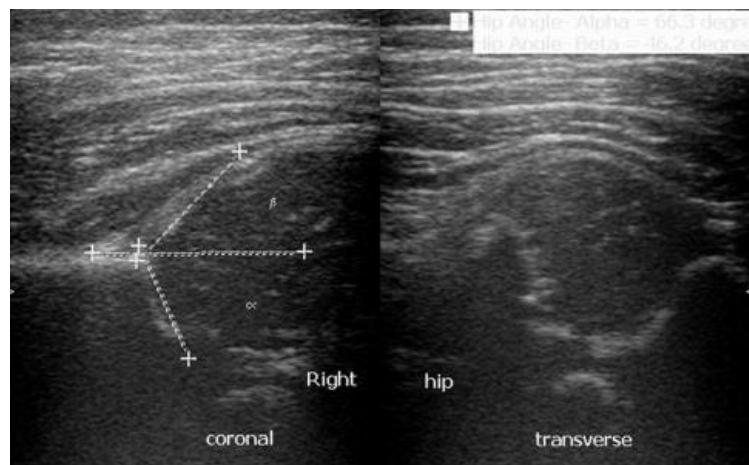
Sonogram of the hip joint (3)
